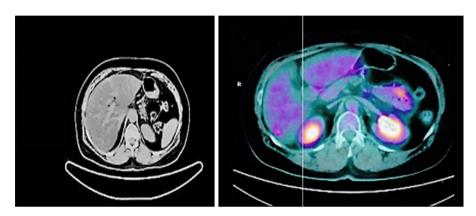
PET-CT (April 2015) after 8 cycles of eribulin shows dimensional reduction of the hepatic lesions (10 mm, SUV max. 8).
